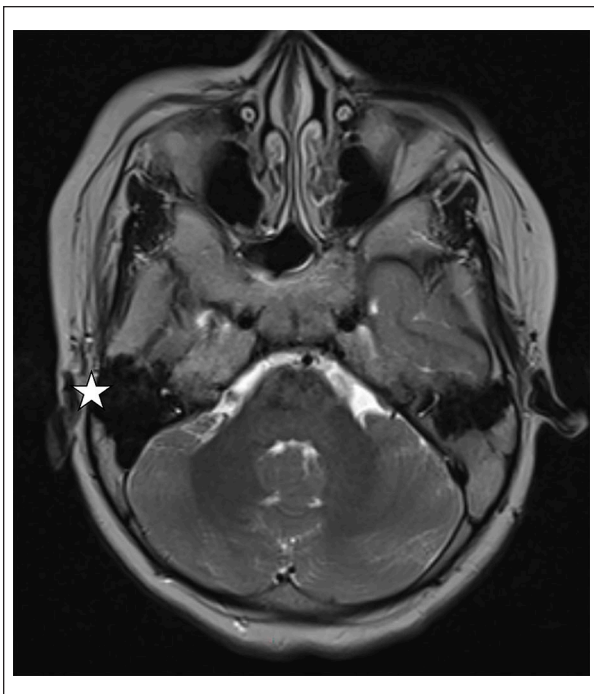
Axial T2 sequence of MRI showing hyperpneumatization of the right mastoid cells (White star).
